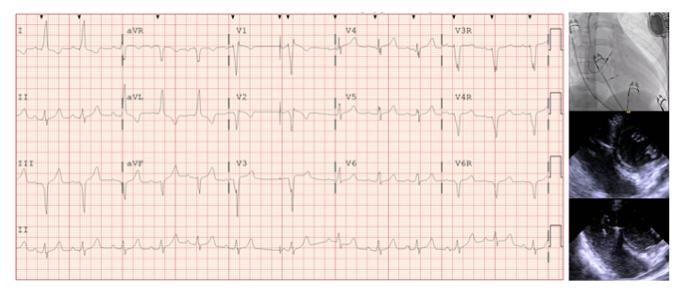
Selective left bundle branch pacing (LBBP) was successfully performed after extraction of a His bundle pacing lead. Electrogram shows selective LBBP, indicated by the presence of right bundle branch delay pattern, V_6 – V_1 R-wave interpeak interval of 44 ms, a pacing stimulus–to–peak R wave (stim-LVAT) of 67 ms, and isoelectric stimulus to QRS interval. Fluoroscopic and transesophageal echocardiographic images demonstrate the position of the LBBP lead.
